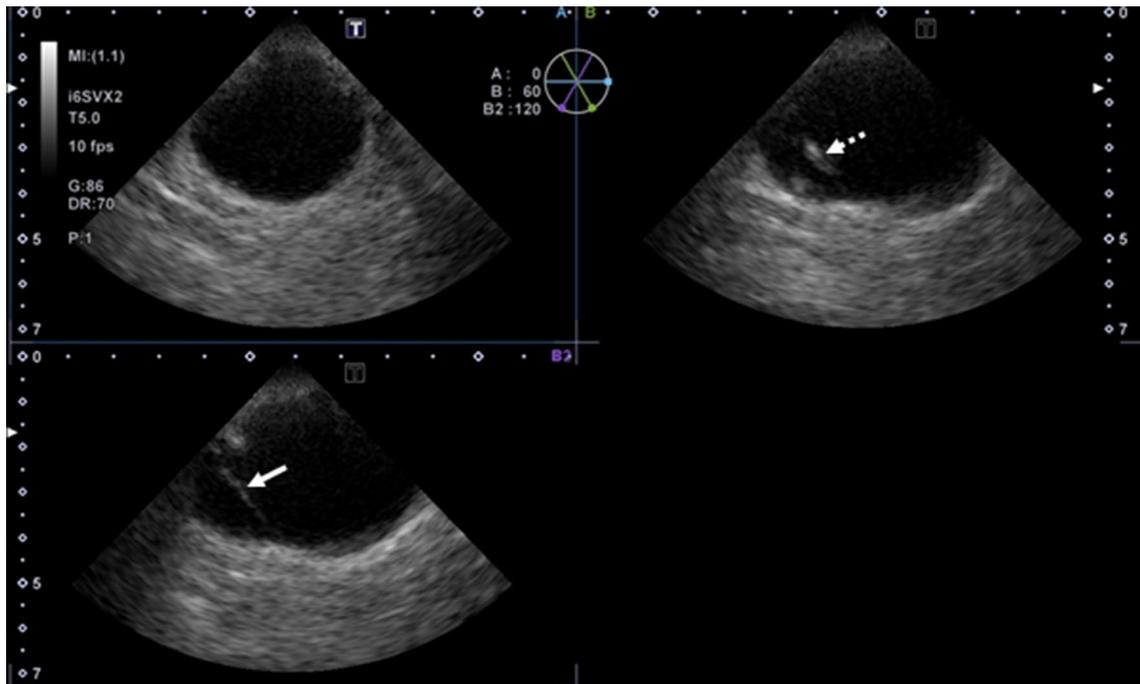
The multi-plane view of the cystic lesion in the pancreas using the transesophageal echocardiography probe. Images from three different directions are shown simultaneously in one screen, demonstrating the septum (arrow) and thickened calcification (broken arrow)
